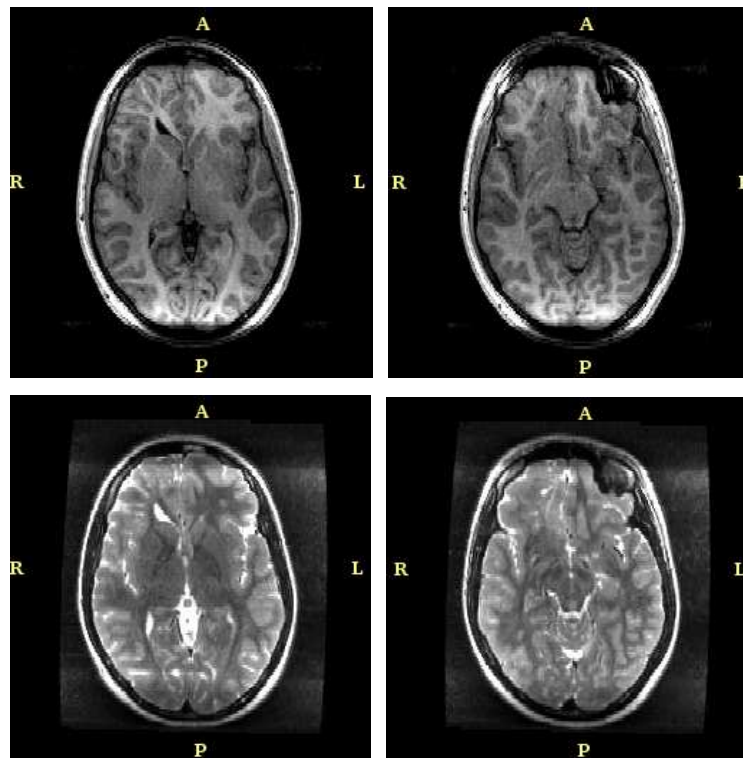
Patient Example 1 - Multi-modal Rigid Registration. Top Row: T1-weighted slices. Bottom Row: Corresponding T2-weighted slices aligned to the T1-weight volume as shown in the top row.
